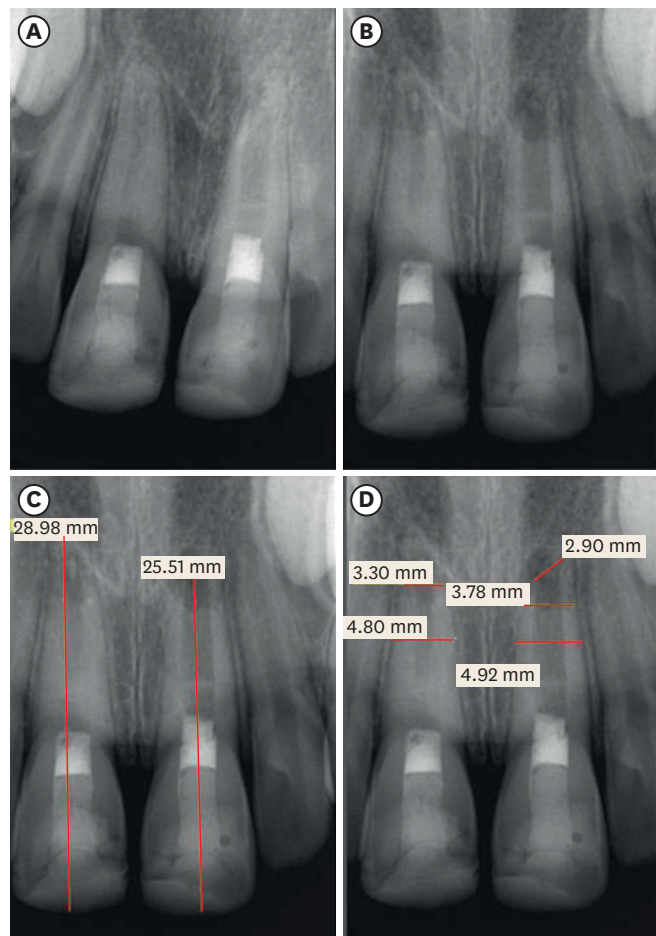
Maxillary left central incisor of 11-years old male patient with open apex and no apical radiolucency due to trauma. Calcium hydroxide was used as an intracanal medicament and the access and part of the canals were filled with mineral trioxide aggregate (A). The 6-months (B) and 12-months (C, D) post-operative radiograph shows the development of periapical radiolucency and the apical foramen failed to close.
